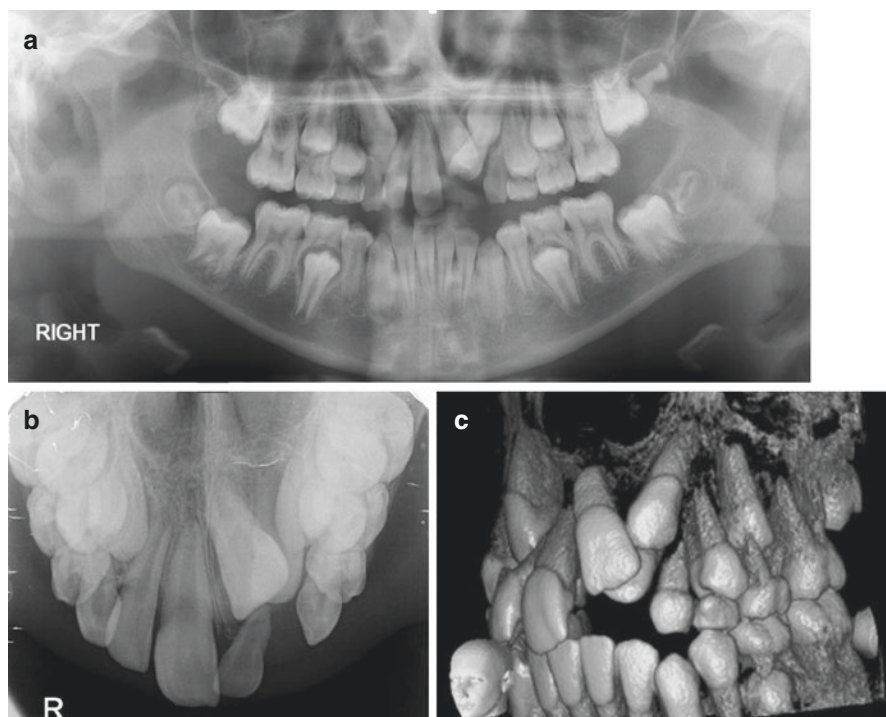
(a) Displacement of the developing maxillary permanent left central incisor may present as delayed eruption of multiple teeth if they become impacted. (b) A standard maxillary occlusal radiograph confirmed the absence of supernumerary teeth which should be considered in the differential diagnosis of delayed eruption of a permanent incisor. (c) Cone beam CT scan may aid surgical planning for the exposure of impacted teeth
